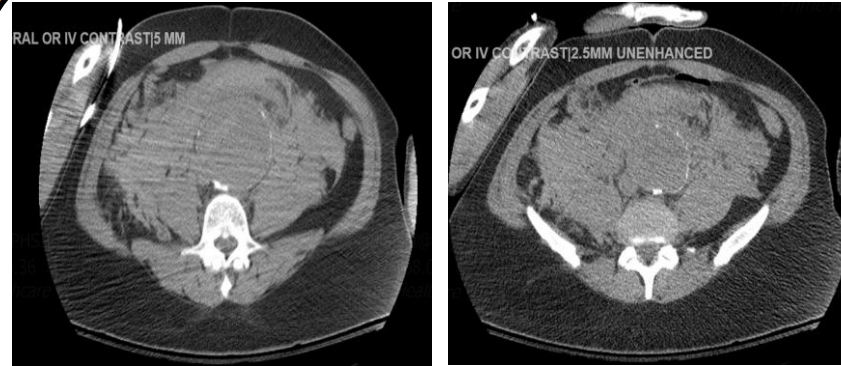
2 showing dilated infra-renal aorta with large retroperitoneal hematoma on CT abdomen and pelvis
